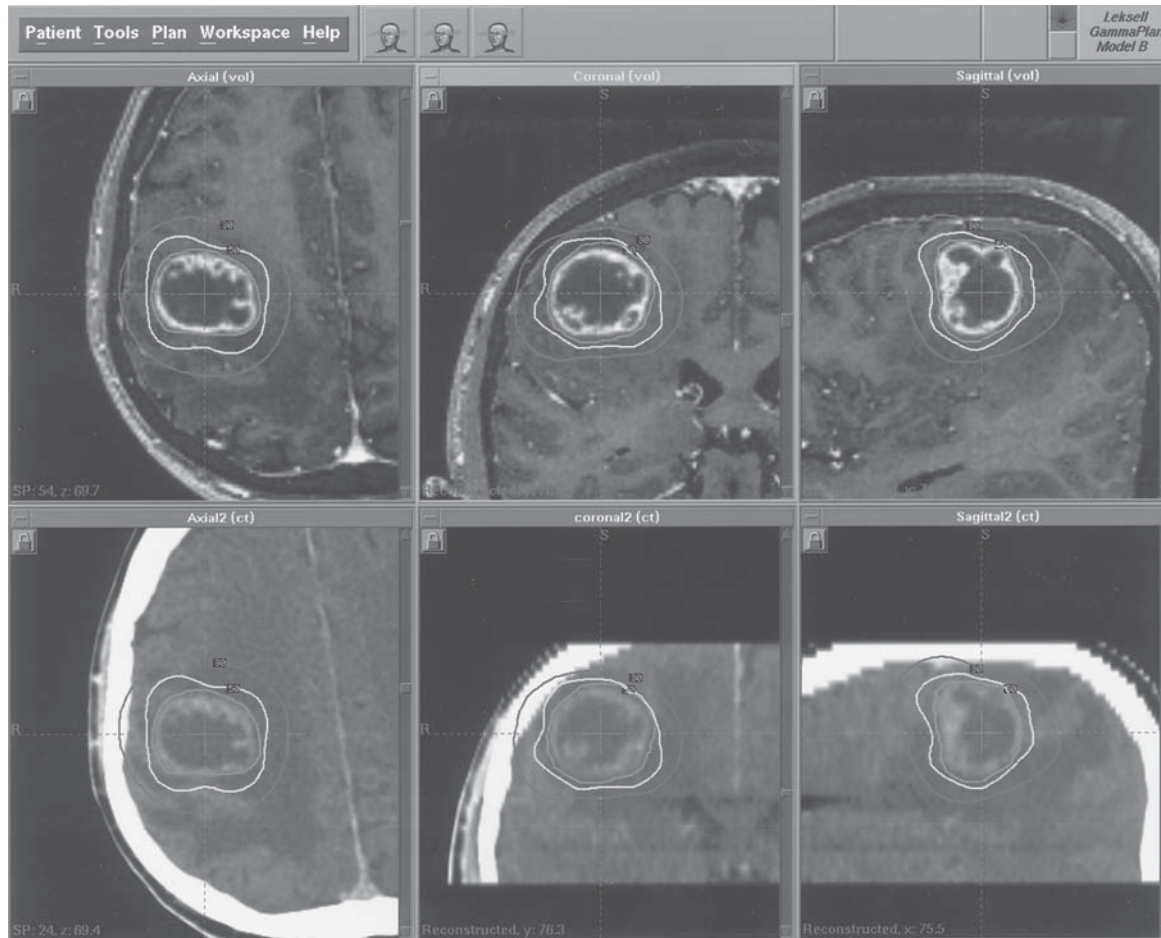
Gamma Knife radiosurgery planning for a patient with metastasis to the right posterior frontal region using multiple targets (11 isocenters or shots). Serial axial, coronal, and sagittal images are shown in the upper (MRI) and lower (CT) panels. 1500 cCy prescribed to the 50% isodose line.
